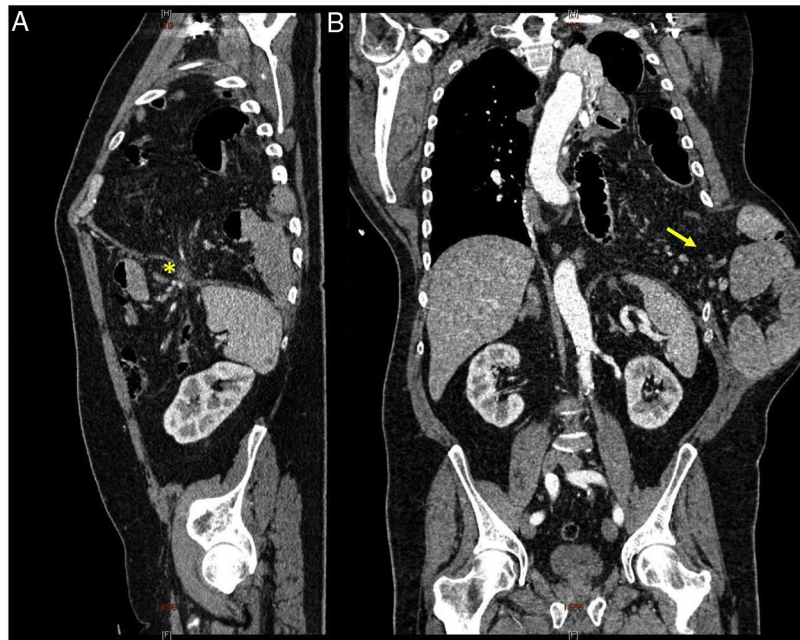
Computed tomography (CT) of the chest and abdomen with administration of intravenous contrast. (A) Sagittal slice: diaphragmatic hernia with a hernial orifice measuring 9×6 cm (*). (B) Coronal slice: bulky hernial sac in the left chest containing dilated bowel loops up to the apex. Part of the contents were herniated between the ninth and tenth left ribs (arrow).
